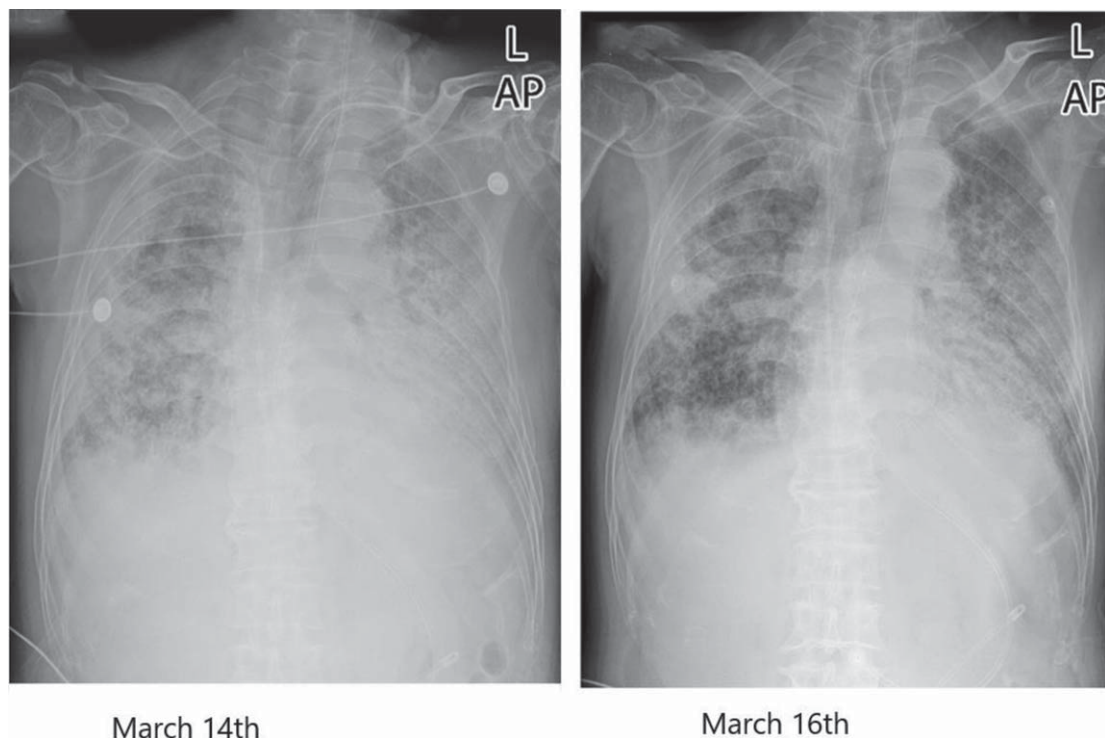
Chest radiograph comparison before and after treatment in case 2.
